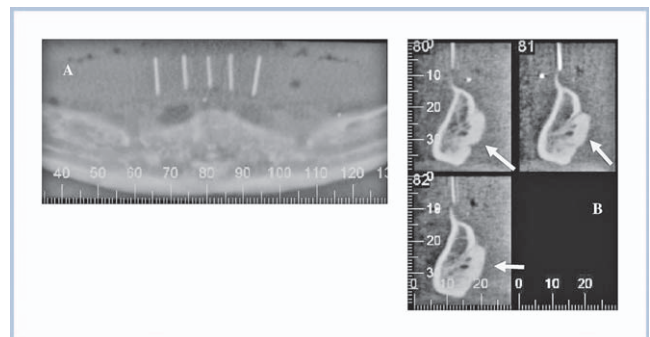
Cone beam CT study performed while the patient was wearing an imaging guide with radiopaque restorative markers seen in the panoramic view (A) and cross sections (B). Each cross-section's number (80, 81, and 83) corresponds with the same number on the panoramic ruler. The markers seen on the panoramic and cross-sectional images represent optimal prosthetically driven trajectories for implants in the anterior region of the mandible, between the right and left mental foramina. Arrows show the anatomic variance.
